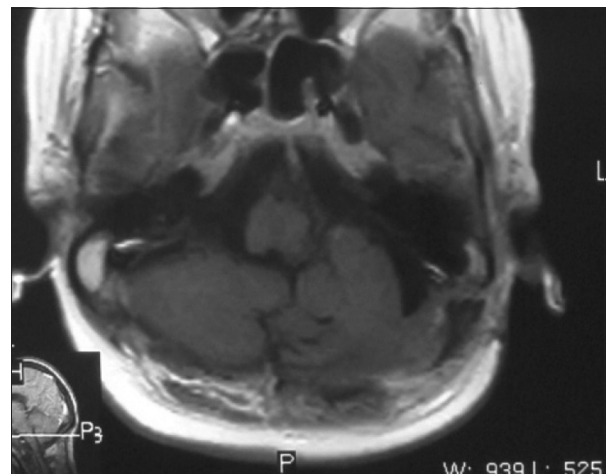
Contrast enhanced sagittal MRI (T1-weighted) showing hypoglossal schwannoma
